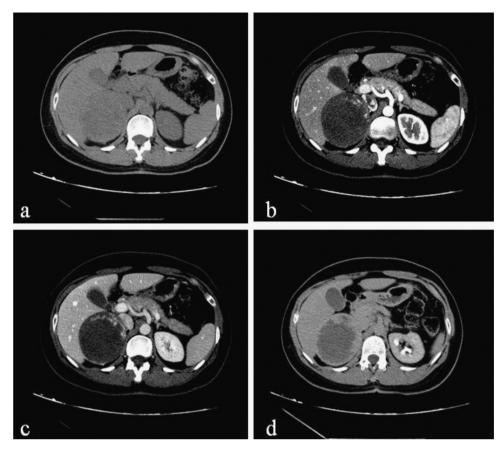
(a) noncontrast-enhanced CT scan showing encapsulate large right adrenal lesion with regular margins; (b-d) contrast-enhanced CT images obtained in arterial, portal and late phase, 3 min after iodinated contrast administration, showing a hypodense centre with no infiltration of peri-adrenal organs.
